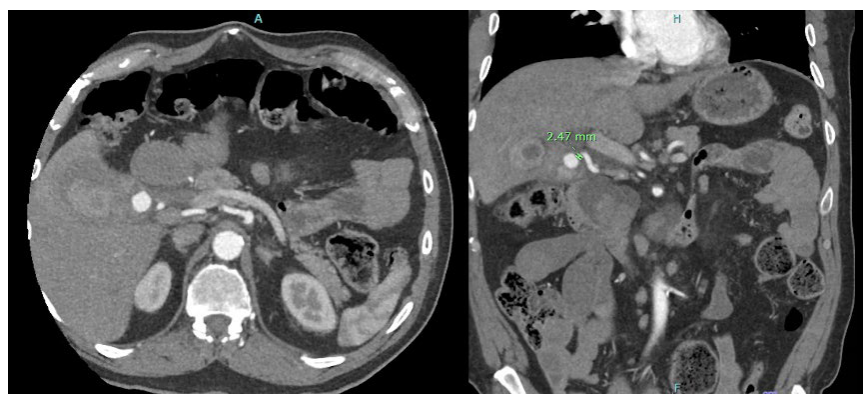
Preoperative CT angiogram demonstrating cystic artery pseudoaneurysm, axial view (left) and coronal view (right).
